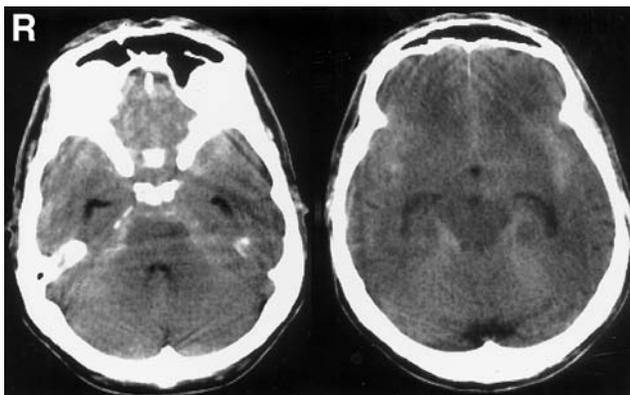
Computed tomography scans on admission showing diffuse subarachnoid hemorrhage predominantly on the left side of the preponine cistern.
